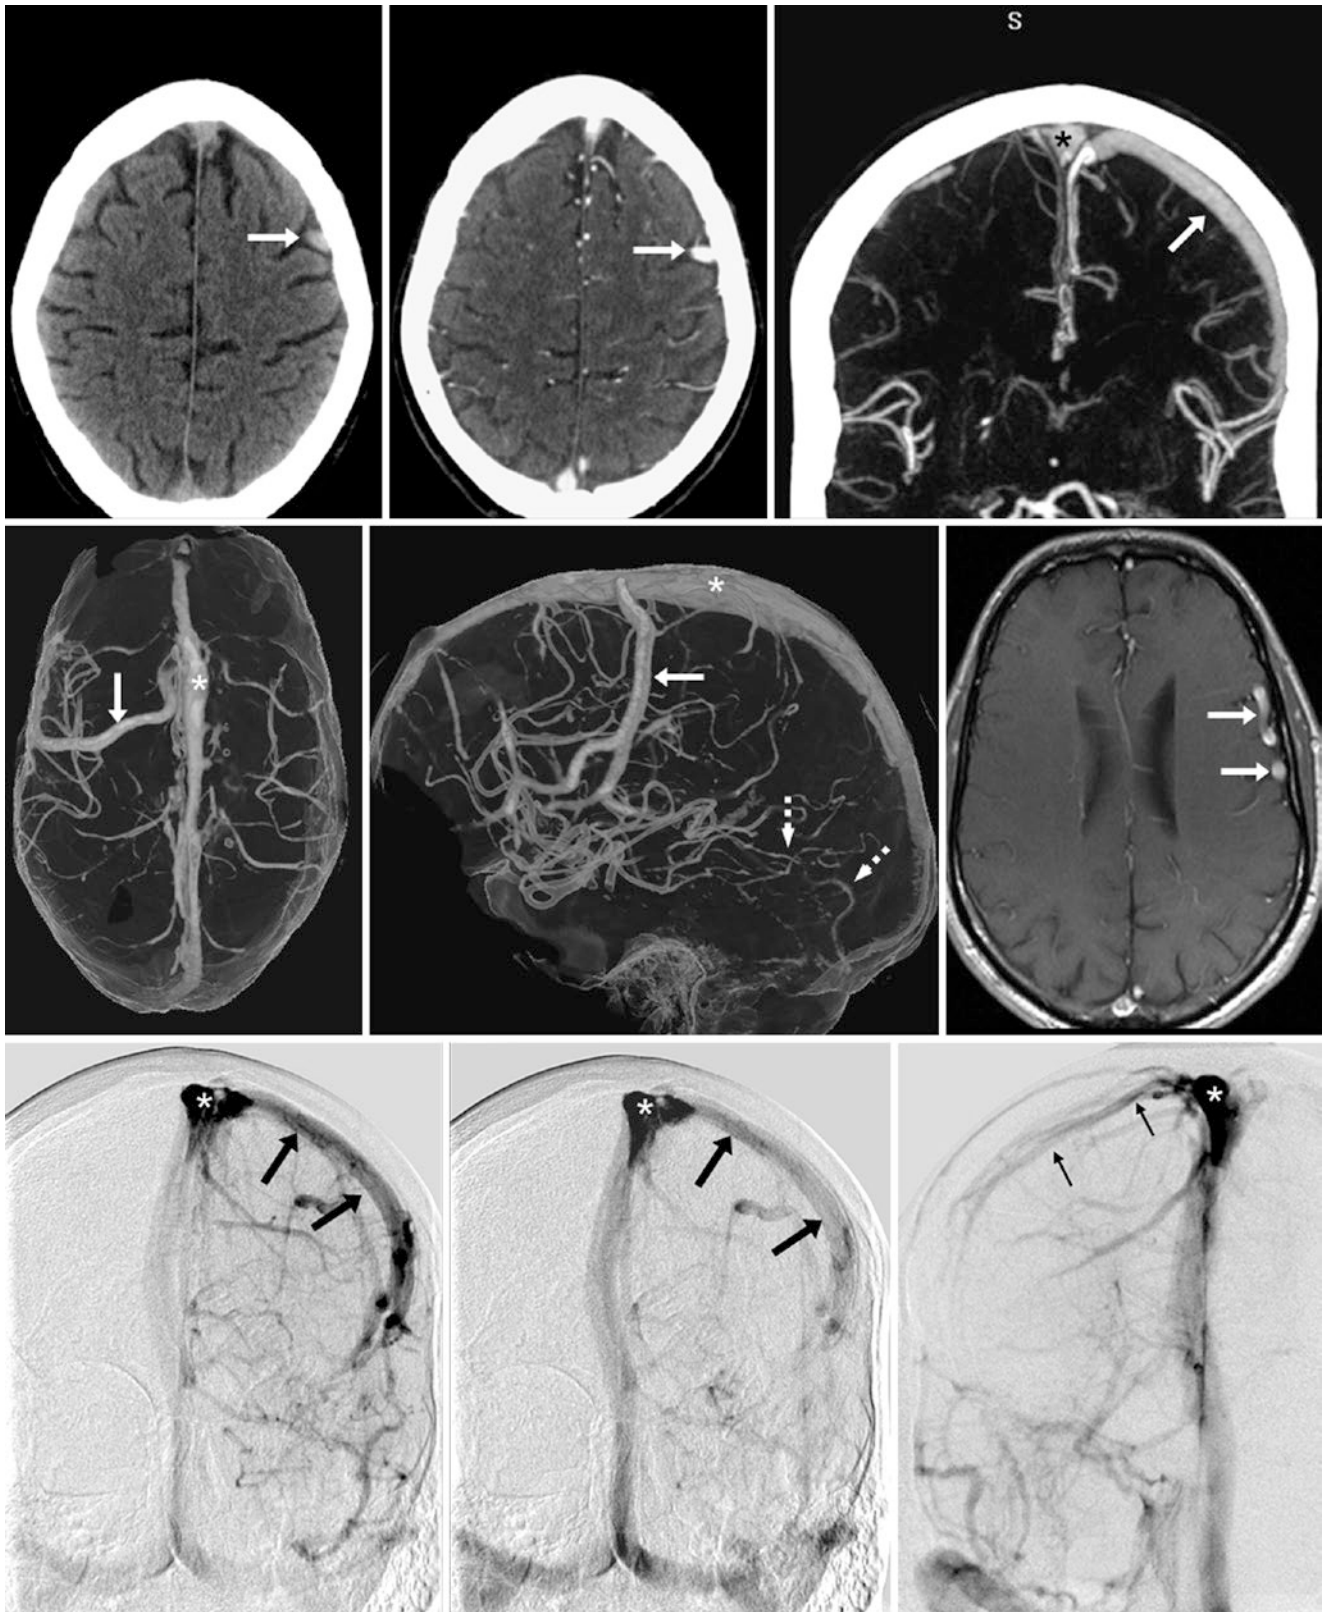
In this 58-year-old, a venous phase CTA was negative. *Top row:* A prominent, dense vein in the left precentral sulcus (*arrows*) on nonenhanced CT (*left*) was shown to be a dominant left VOT on CTV with axial (*middle*) and coronal 20 mm thick (*right*) images. *Middle row:* 3D VR CTV “see through” superior (*left*) and left lateral (*middle*) views
